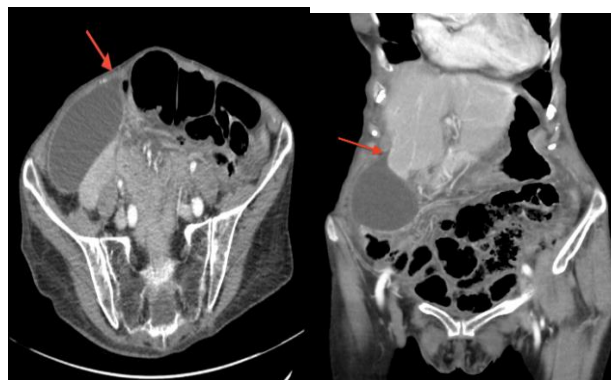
Coronal and sagittal CT slices demonstrating “beak sign” (red arrow) with distended gallbladder.
